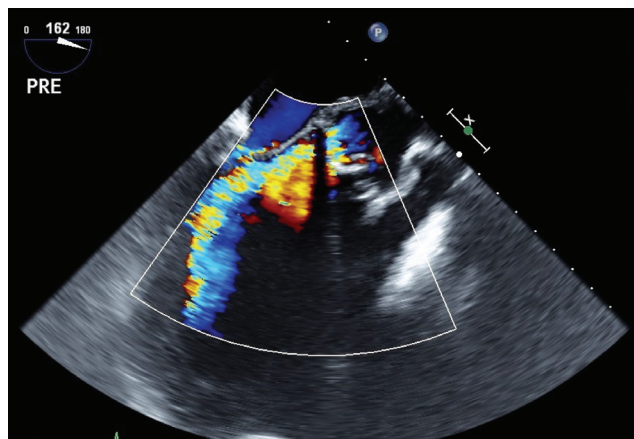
Transesophageal echocardiogram of severe aortic regurgitation at the level of the Freestyle bioprosthesis.
